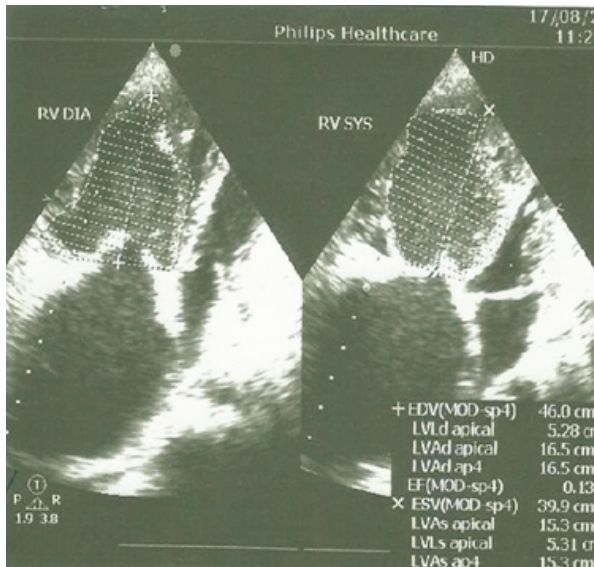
2D-Echocardiography
